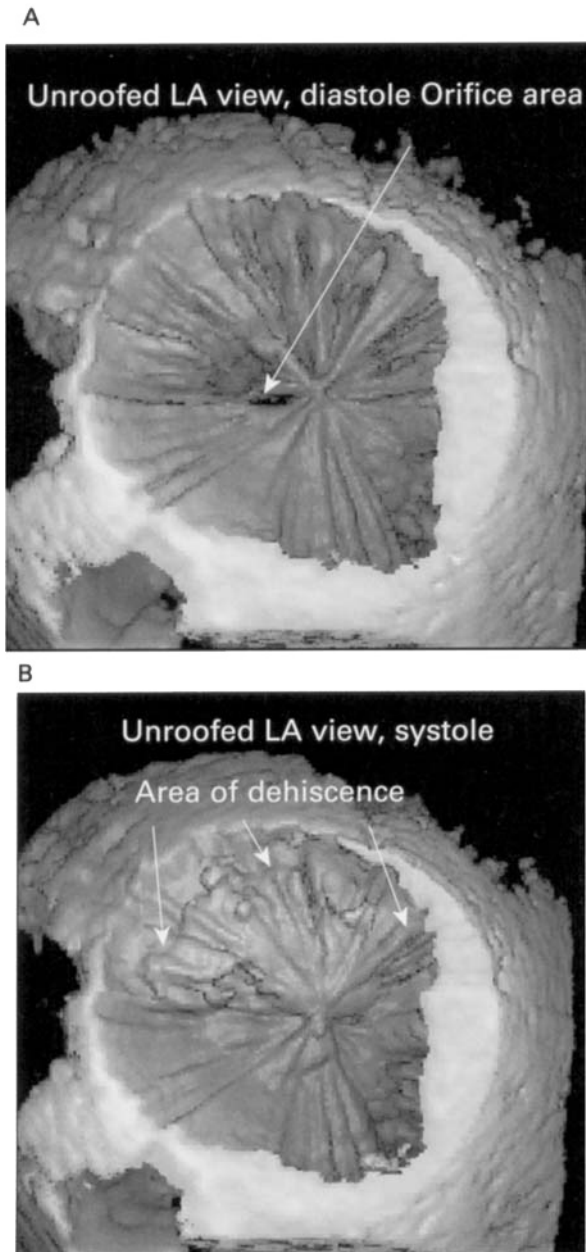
Volume rendered three-dimensional transoesophageal echocardiographic image, showing an unroofed left atrial view with an irregular aspect of the prosthetic orifice in (A) diastole due to obstruction by vegetations and (B) the area of dehiscence in systole.
